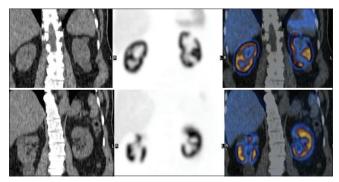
Selected coronal computed tomography, positron emission tomography, and positron emission tomography/computed tomography fusion images of the kidneys demonstrate multiple renal parenchymal defects on positron emission tomography corresponding to the multiple cysts seen on computed tomography images (arrows)
